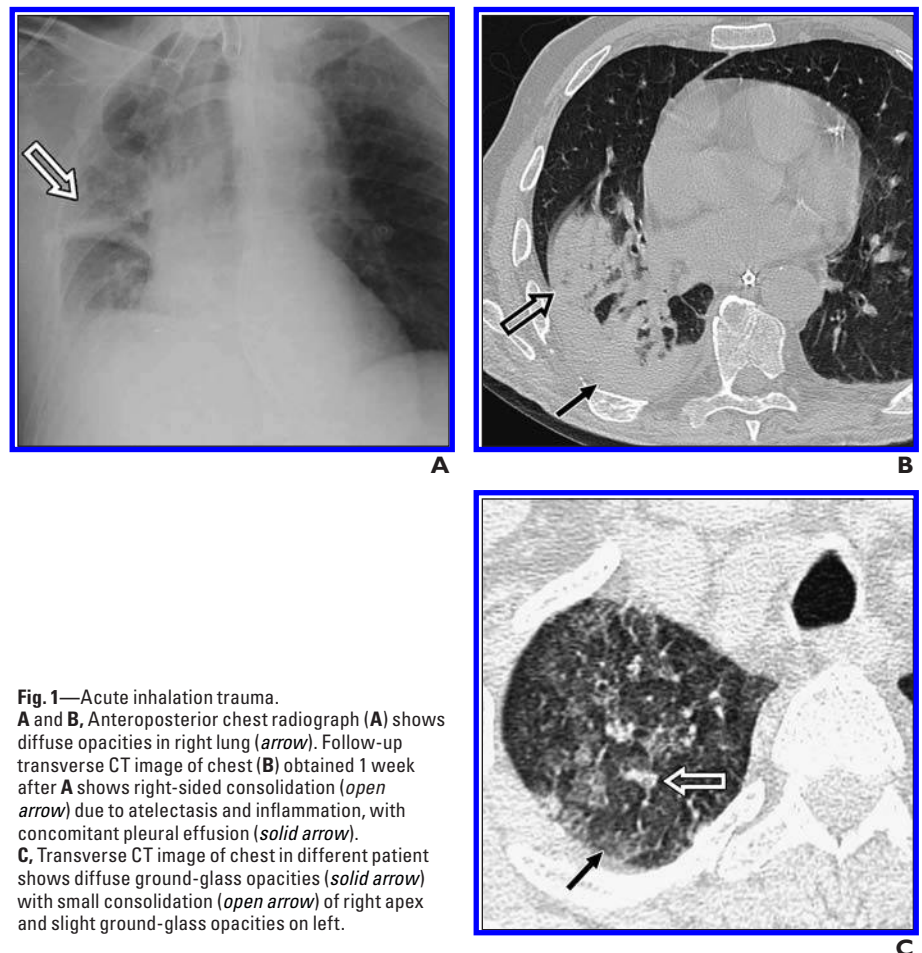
Acute inhalation trauma. A and B, Anteroposterior chest radiograph (A) shows diffuse opacities in right lung (*arrow*). Follow-up transverse CT image of chest (B) obtained 1 week after A shows right-sided consolidation (*open arrow*) due to atelectasis and inflammation, with concomitant pleural effusion (*solid arrow*). C, Transverse CT image of chest in different patient shows diffuse ground-glass opacities (*solid arrow*) with small consolidation (*open arrow*) of right apex and slight ground-glass opacities on left.
